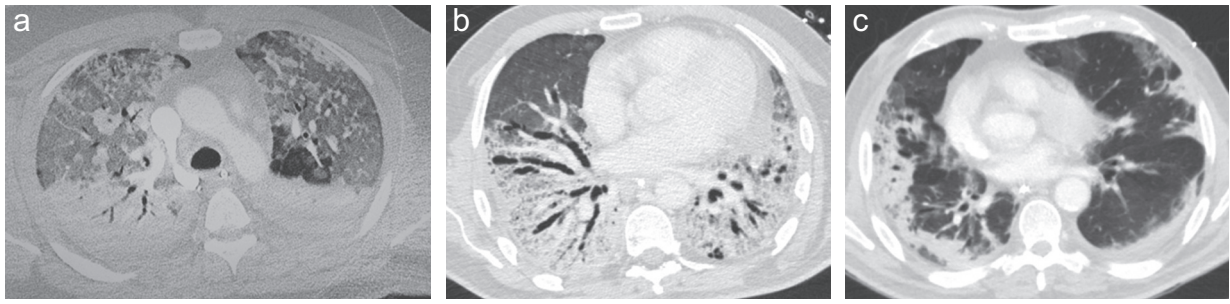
Admission CT of three coronavirus disease 2019 (COVID-19) patients requiring retrieval to the severe respiratory failure unit at Guy’s and St. Thomas’ NHS Foundation Trust after extracorporeal membrane oxygenation implantation at the referring centre. (a) A 44-yr-old male referred after 5 days of invasive ventilation. CT shows classical acute respiratory distress syndrome pattern with diffuse ground glass opacities and dorsal consolidation/atelectasis. Required standard intensive care therapies and no immunomodulation. (b) A 52-yr-old male with CT demonstrating more extensive parenchymal distortion/fibrosis and traction bronchiectasis typical of acute interstitial pneumonitis or Hamman-Rich syndrome after 7 days of invasive ventilation and preceding noninvasive ventilation. Pulsed methylprednisolone (500 mg for 3 days) utilised followed by tapering course. (c) A 32-yr-old male admitted with severe respiratory failure, vasoplegia (norepinephrine $1.7 \mu\text{g kg}^{-1} \text{min}^{-1}$), and normal biventricular function related to cytokine release syndrome. Ferritin of $12\,000 \text{ ng ml}^{-1}$ and CT appearances of cryptogenic organising pneumonia with occasional reverse halos noted (Atoll sign). Immunomodulation in the form of i.v. immunoglobulin, methylprednisolone 1 mg kg^{-1} twice daily, and anakinra.
